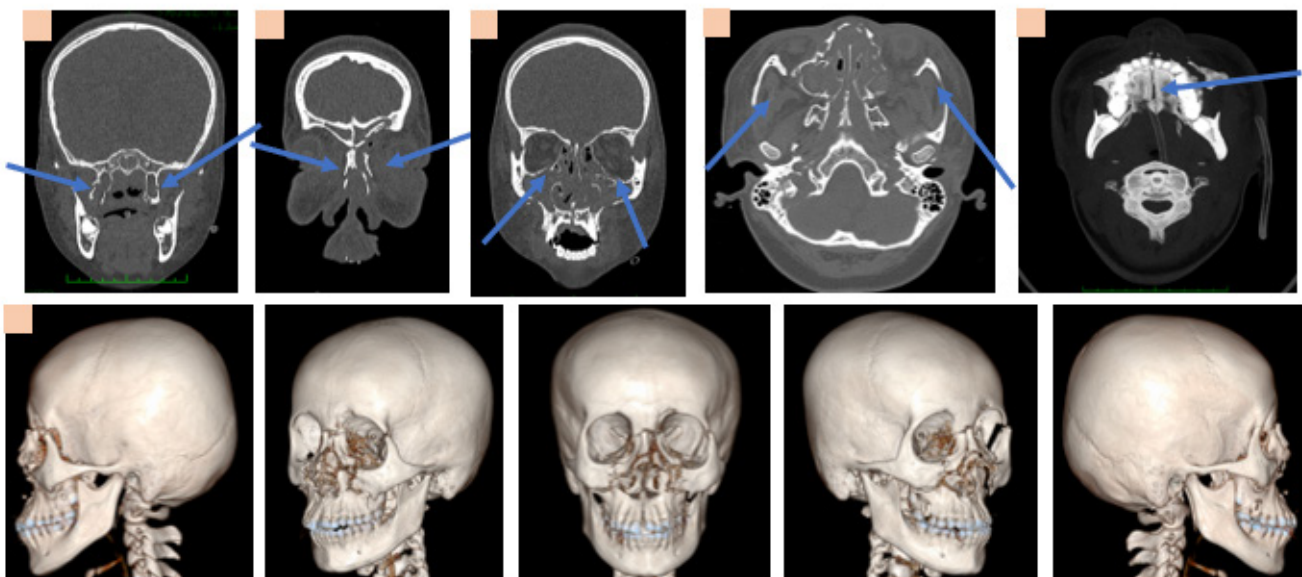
Pre-Operative CT Scan Showed Bilateral Le Fort Type I and II and Complete Sagittal Palatal Fracture. A) Fracture of pterygoid bones (arrows). B) Comminuted fracture of nasal bone (arrows). C) Displaced fracture of the medial & inferior rim of the bilateral orbit (arrow). D) Axial CT image, reveals both zygomatic arches were intact (arrows). E) Complete sagittal palatal fracture; F) Three-dimensional image
